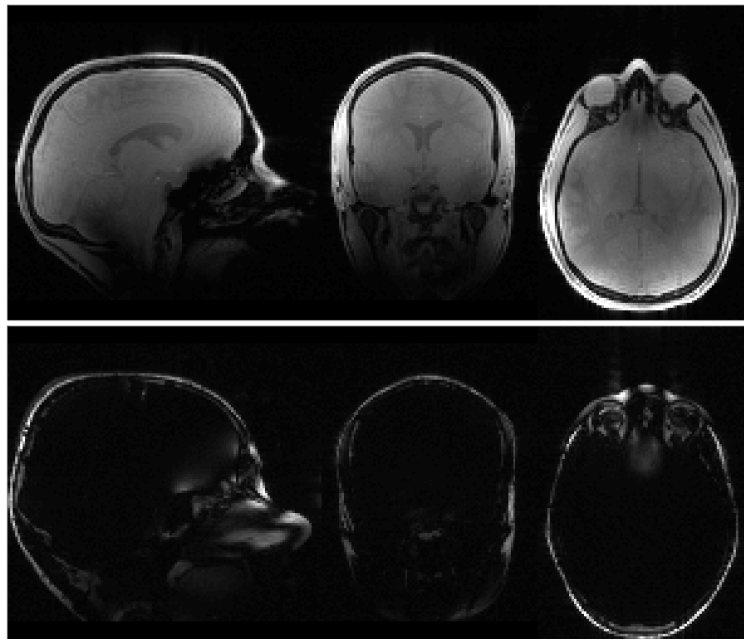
Orthogonal views of water (top) and fat (bottom) signal sources standardly found in head MRI.
